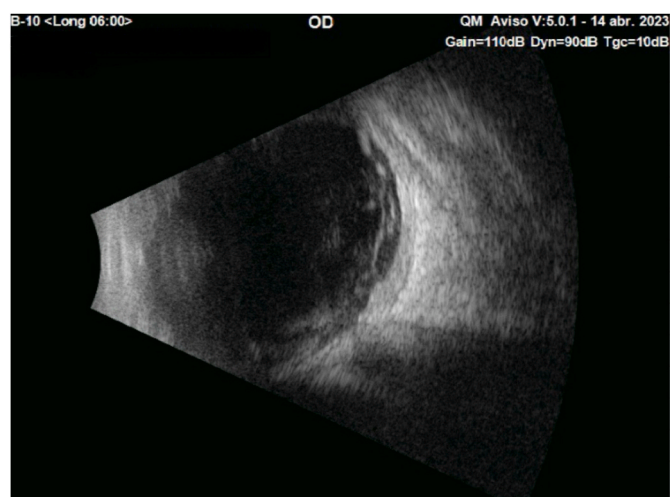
Ultrasound in B-scan.
